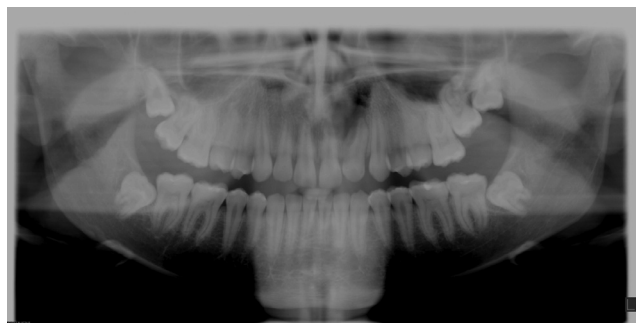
Panoramic x-ray: abnormal root shape (tooth 22). (The tooth has 2 roots.)
